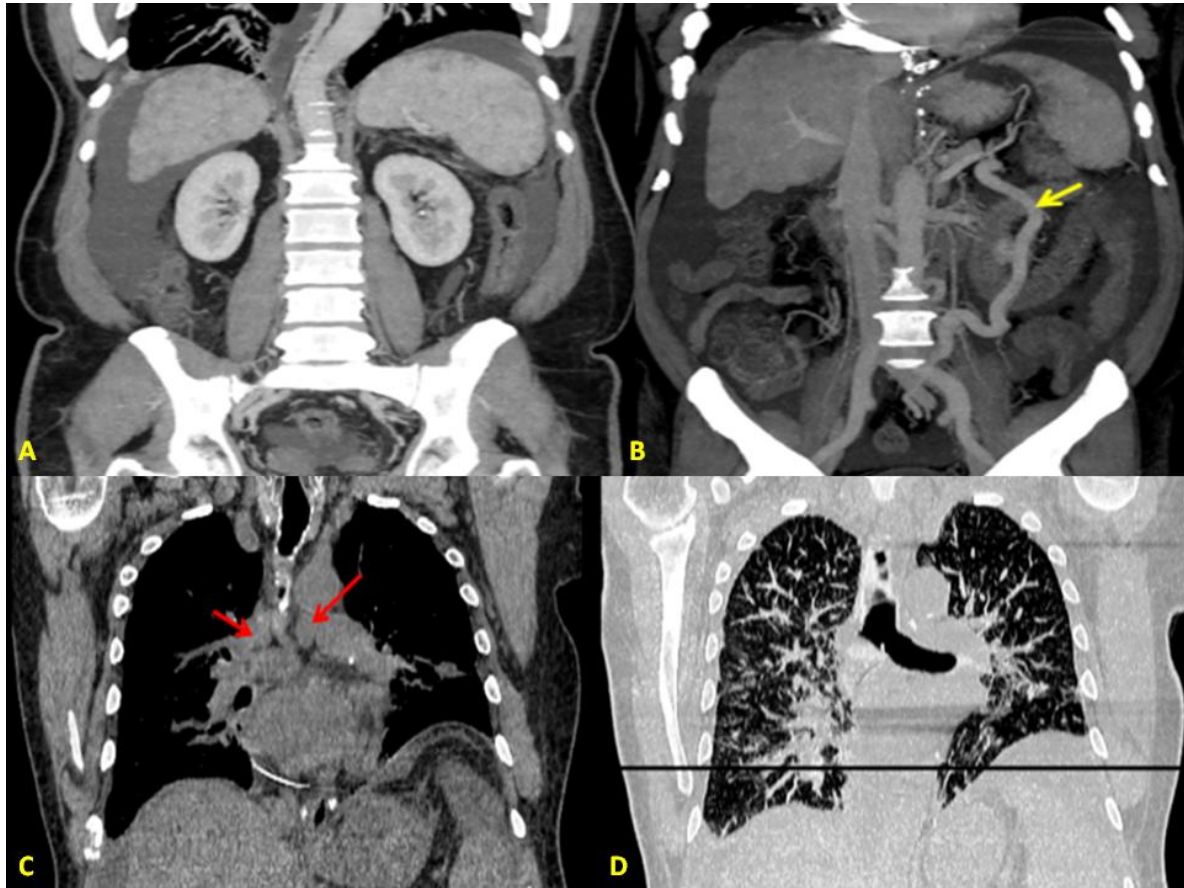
Computed tomography of abdomen and chest showing features of cirrhosis with multiple hypodense nodules in the liver (A) along with presence of abdominal collaterals (B, yellow arrow), multiple enlarged mediastinal nodes (C, red arrows) and extensive reticulonodular lesions in the lung (D), features suggestive of thoracic sarcoidosis.
